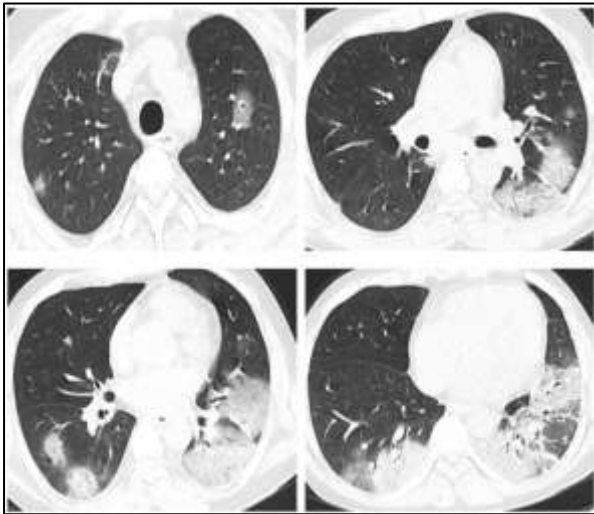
Axial CT sections of the chest in lung window in a 29-year-old male. Multiple peripheral ground-glass opacities with consolidations predominantly in bilateral lower lobes. CT severity score was 14/25. This patient had elevated levels of CRP, IL-6, and LDH.
